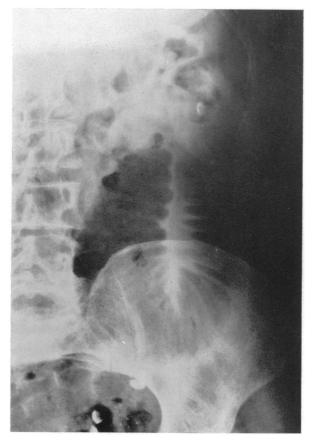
(a). Straight X-ray showing air-filled dilated loop of jejunum.
